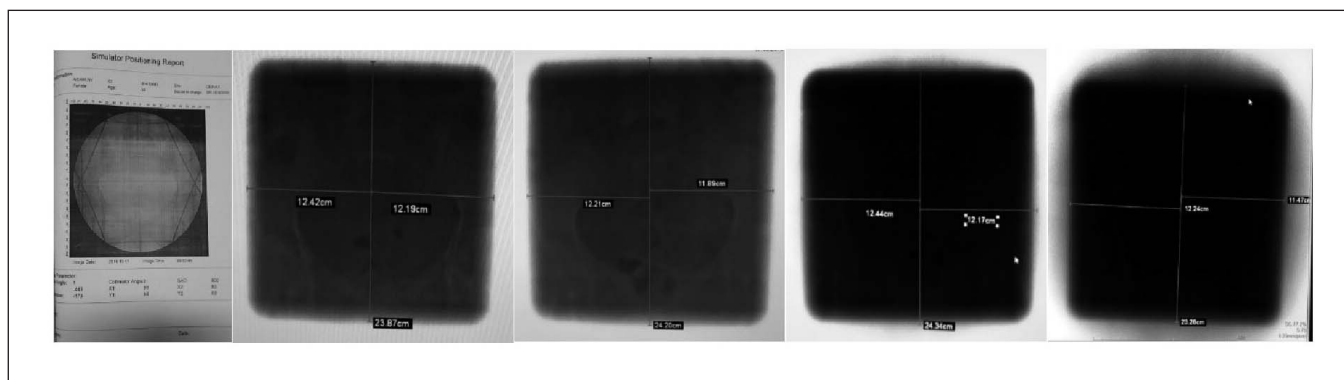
Radiation field verification using computer radiography
